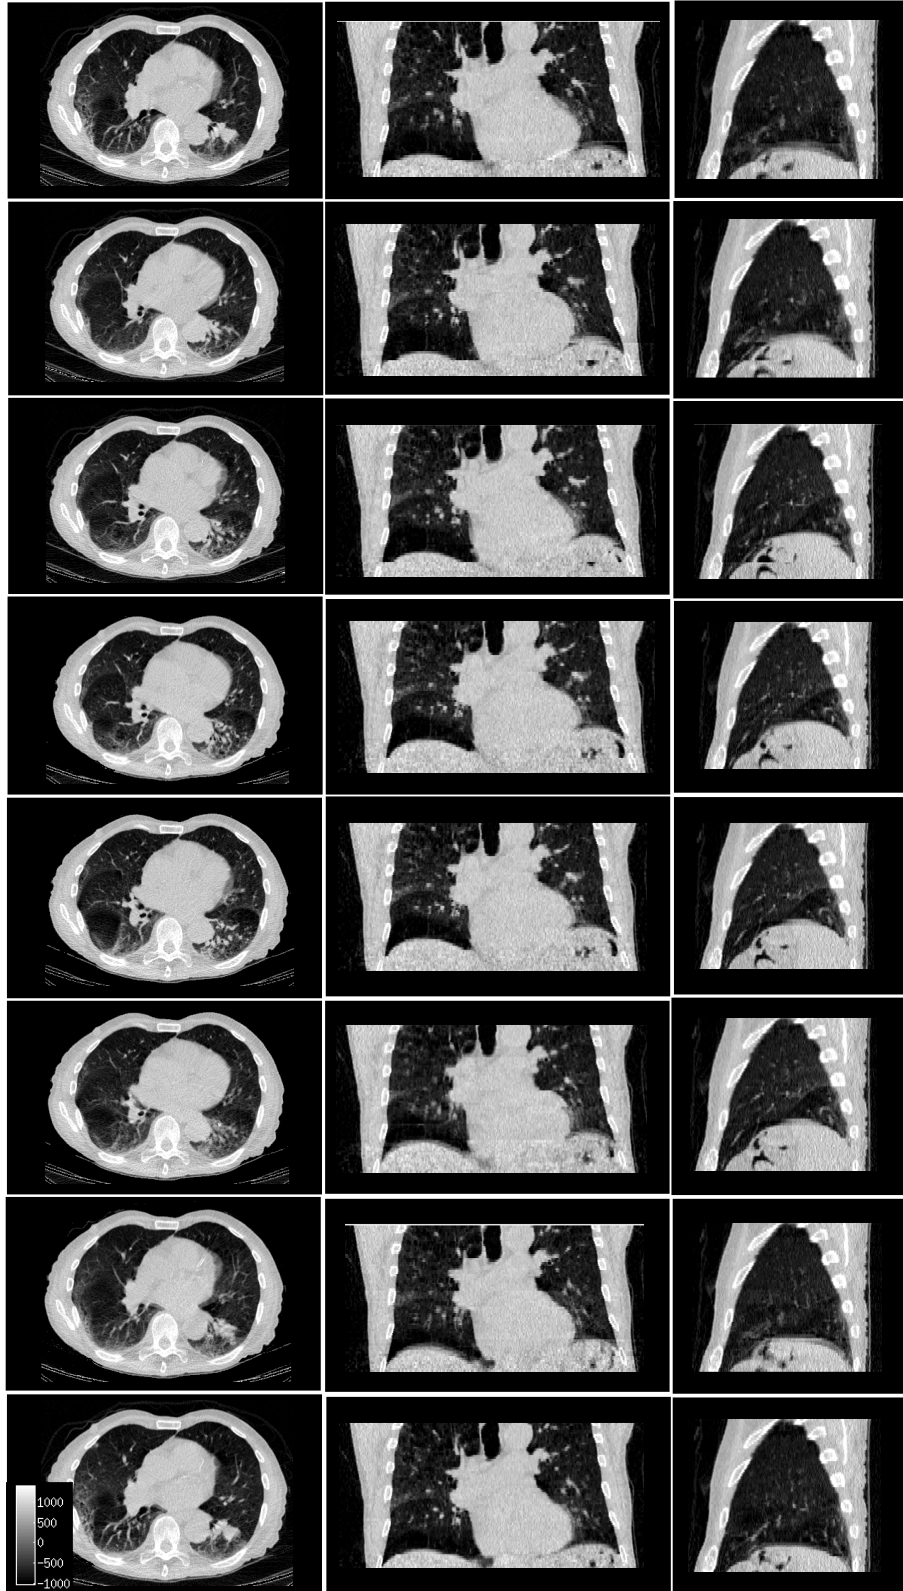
Examples of the gated CT images from Gate 1 to 8 in HU units of a patient in the transverse, coronal, and sagittal planes, respectively.
